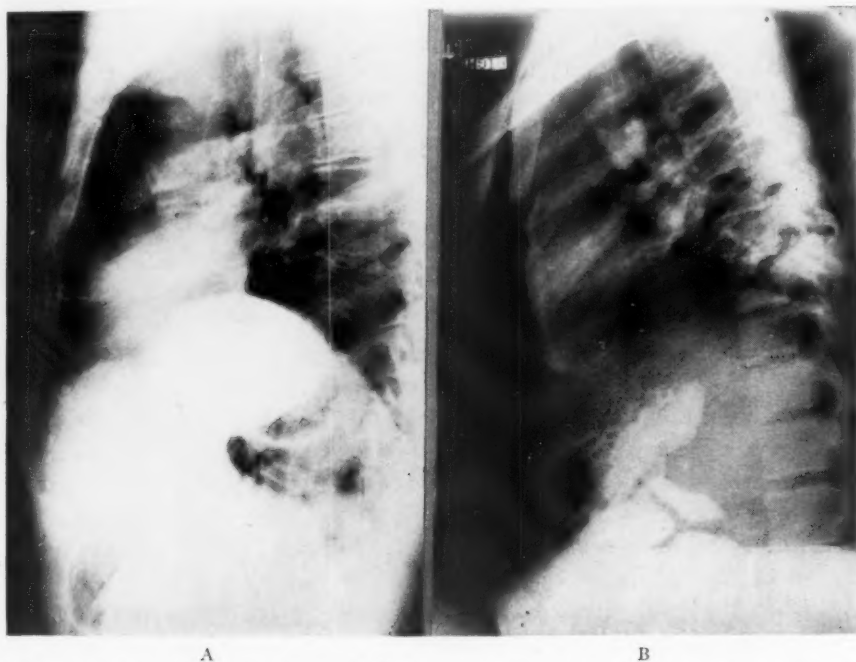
Lateral roentgenograms showing (A) the normal relationship of stomach to diaphragm; and (B) the downward displacement of the stomach by the subphrenic abscess in Case 4.
